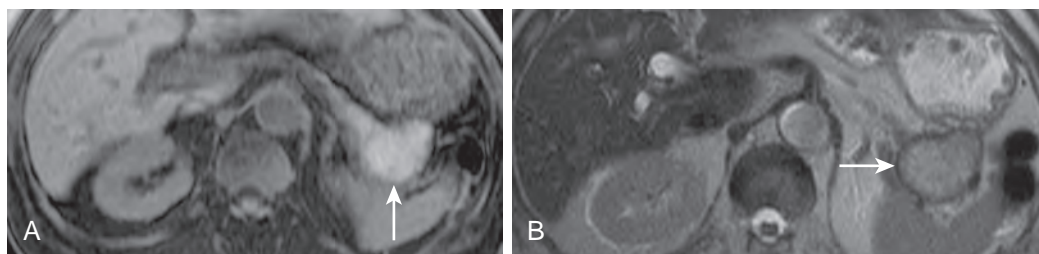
Pancreatitis with hemorrhagic pseudocyst. A. Axial T1-weighted fat-suppressed spoiled gradient-echo MR image shows pseudocyst (arrow) in the pancreatic tail with high signal intensity from hemorrhagic content. B. Axial T2-weighted HASTE MR image shows low signal intensity rim of hemosiderin in pseudocyst (arrow). The diagnosis of hemorrhage is easily made on MRI because of the hemosiderin rim. (A and B from Miller FH, Keppke AL, Dalal K, et al: MRI of pancreatitis and its complications: Part 1, acute pancreatitis. *AJR Am J Roentgenol* 183:1637–1644, 2004. Reprinted with permission from the American Journal of Roentgenology.)
